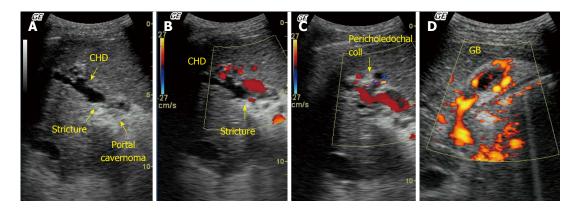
Ultrasound with Doppler in a patient with extrahepatic portal venous obstruction and portal biliopathy. A: Gray scale image shows an echogenic mass in hilum (portal cavernoma). Common hepatic duct (CHD) shows dilatation and luminal irregularity with a stricture at the level of the cavernoma; B: Color Doppler image showed multiple pericholedochal collaterals around the strictured bile duct (arrow); C: Color Doppler image shows pericholedochal collaterals and recanalized irregular portal vein; D: Power Doppler images of gall bladder. Gall bladder wall is thickened with multiple collaterals within the gall bladder wall.
